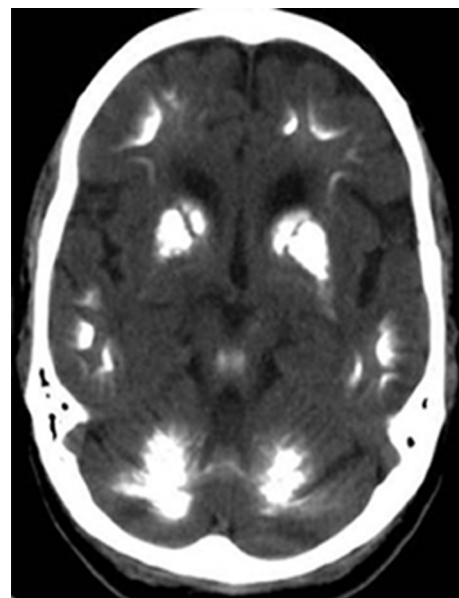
Unenhanced CT image showing dense calcification in the dentate nuclei, basal ganglia and cerebral white matter in a case of Fahr's disease.
